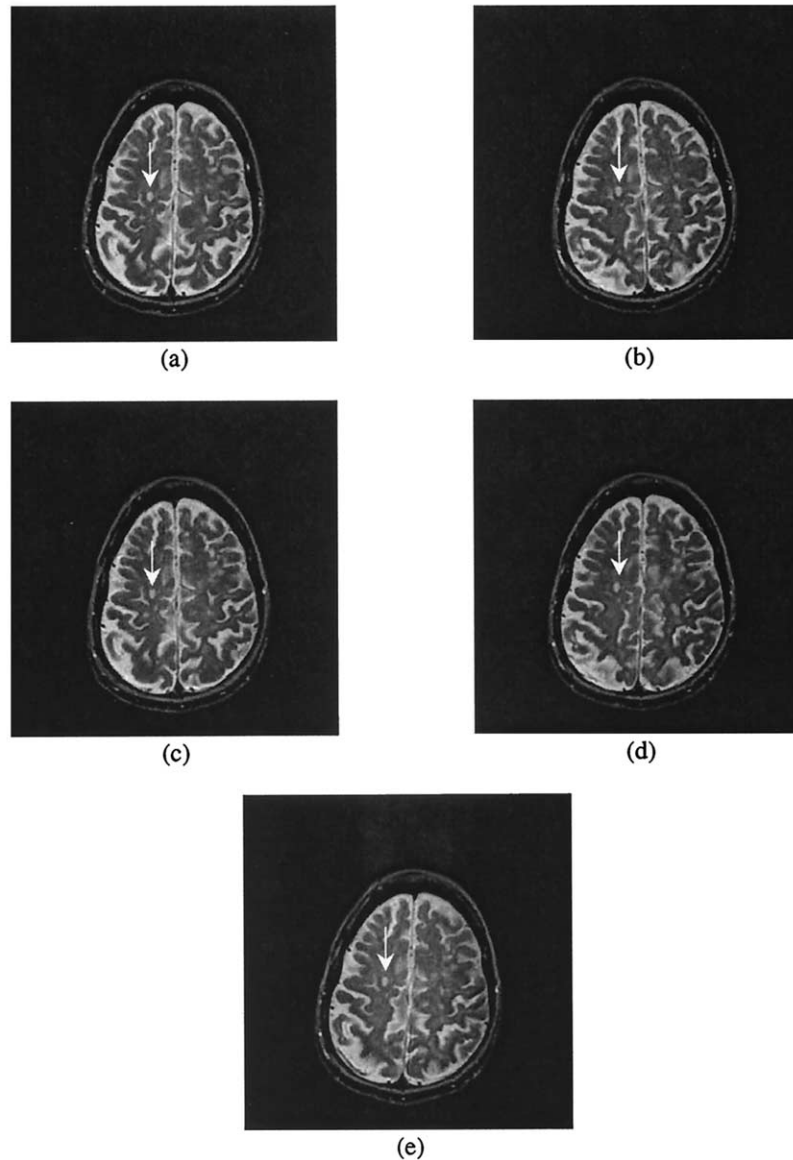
(a–e) An in vivo MRI slice belonging to each one of the five sets of images, respectively, showing one of the analyzed MS lesions (white arrow). The differences between the images and the 2D shape of the lesion can be noted.
